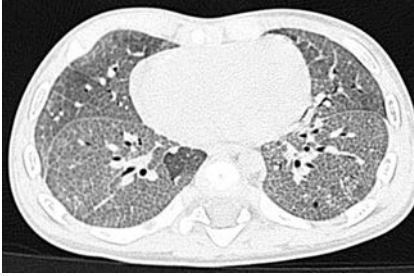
HRCT scan of an infant with SP-C deficiency and presentation of chILD syndrome at 6 months of age. Note the crazy paving pattern in both lower lobes.
